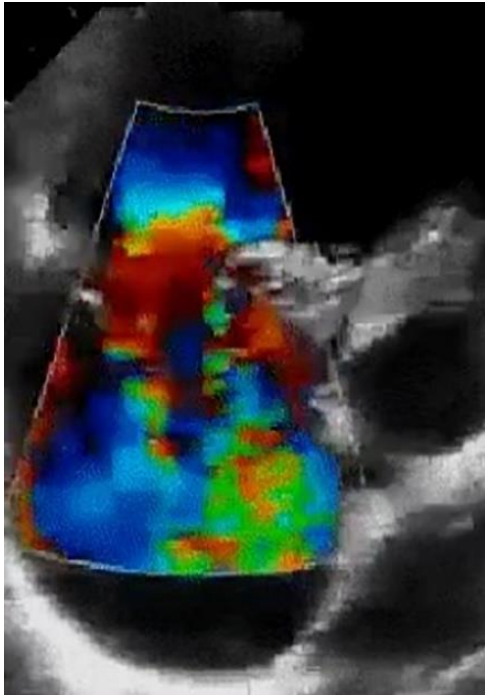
Color flow doppler ultrasound of the cardiac apical chamber. Case courtesy of David Carroll, Radiopaedia.org, rID: 64272
